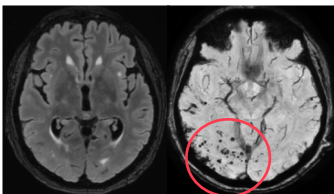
Follow-up axial FLAIR and SWAN
